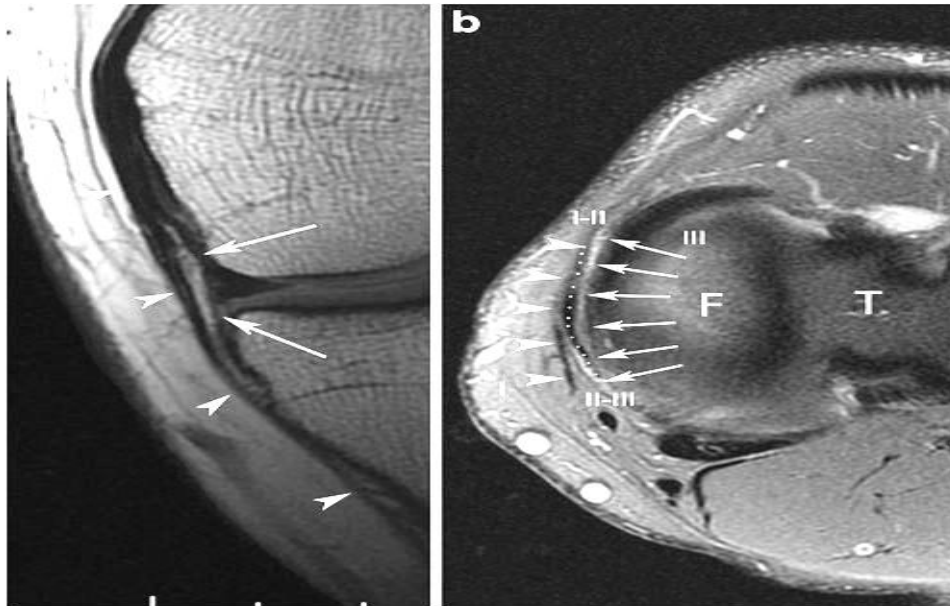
Normal MCL anatomy. a Coronal T1-weighted image. The sMCL courses from its femoral attachment at the medial epicondyle to its proximal and distal tibial attachments (arrowheads). The dMCL (arrows). b Axial proton density fat saturated image. the deep crural fascia (arrowheads), while (dotted line) contains the sMCL and (arrows) contains the dMCL (*Schein et al., 2012*).
